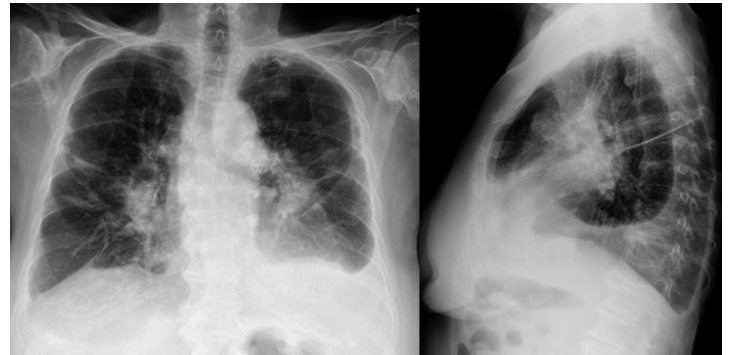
Plain chest radiograph, A/P and lateral views showing small, bilateral loculated pleural effusions.
